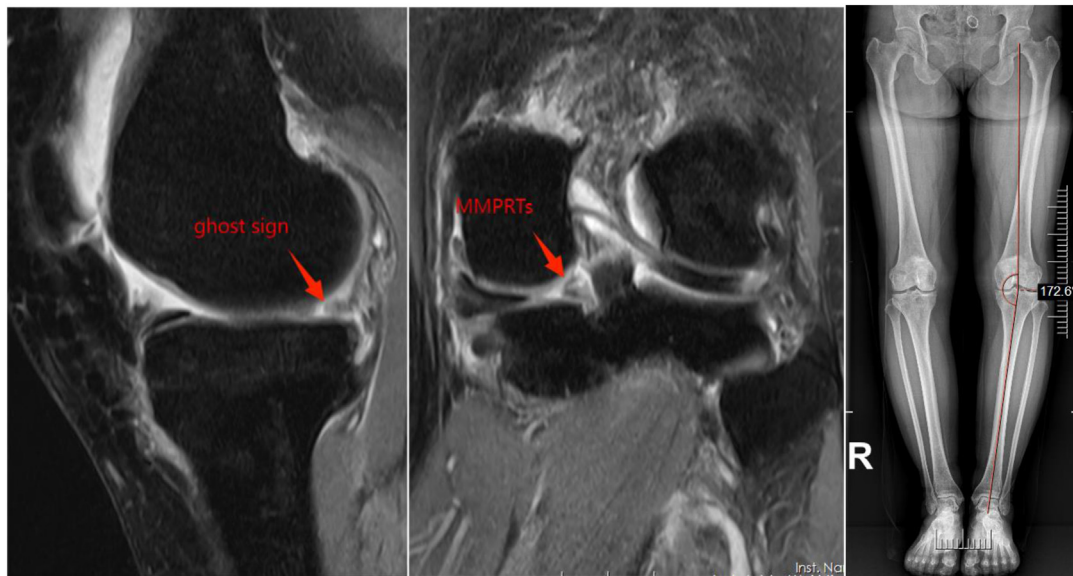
Sagittal and coronal MRI of the left knee showed the meniscus posterior root tears, and full-length x-ray of the lower limb showed an inversion deformity greater than 5°. (MMPRT, medial meniscus posterior root tear.)
